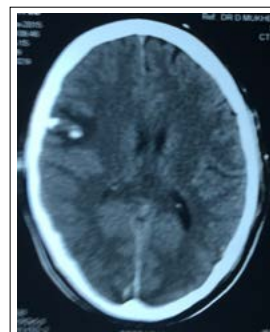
Plain CT scan Head 2 hours after head injury
